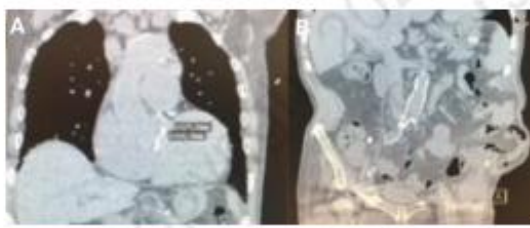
[A] Preoperative native computed tomography [CT] scan to measure aortic valve annular size, coronary ostia distances, and left ventricular outflow tract morphology. [B] CT scan of iliofemoral vessel anatomy.
